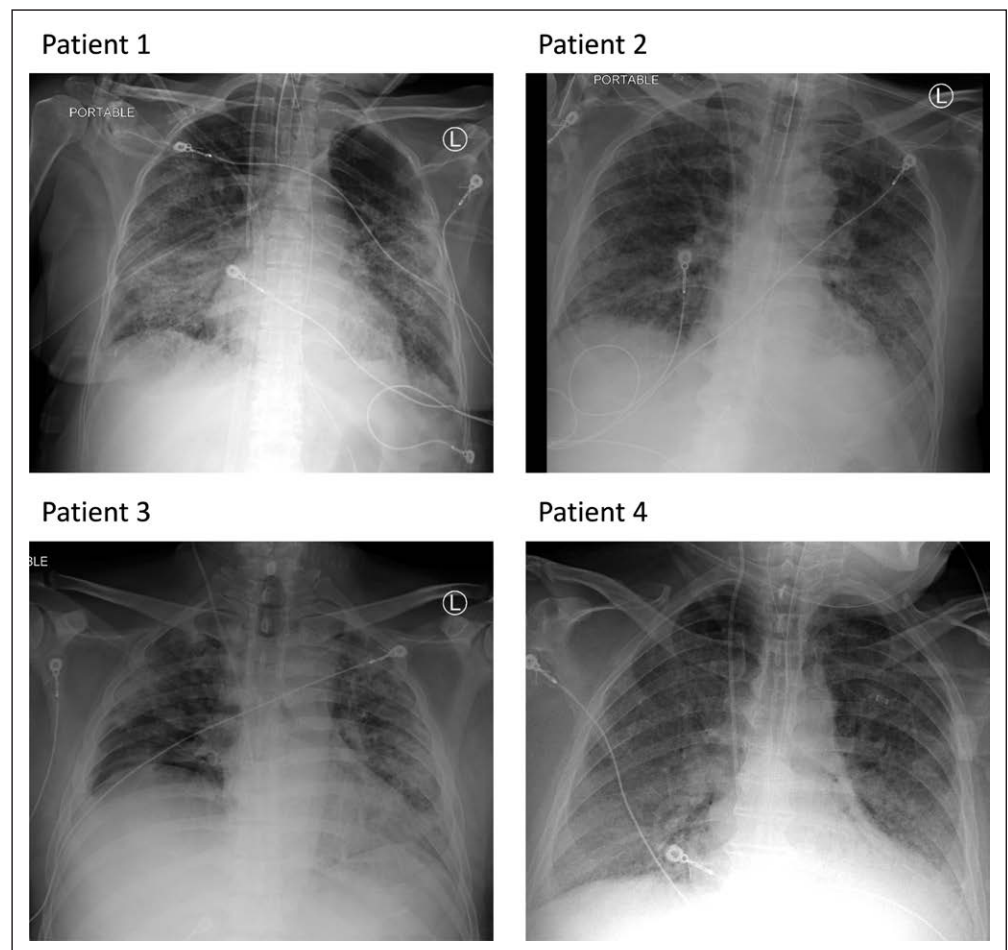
Chest radiographs from each patient at time of admission to the ICU. L = left side of the chest.
